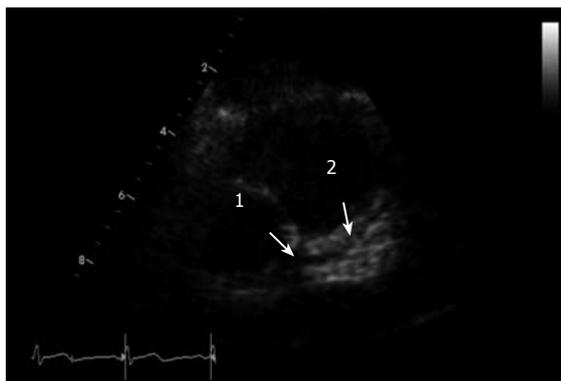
Echocardiogram-parasternal short-axis view showing normal left main coronary artery (1), normal left anterior descending artery (2).
